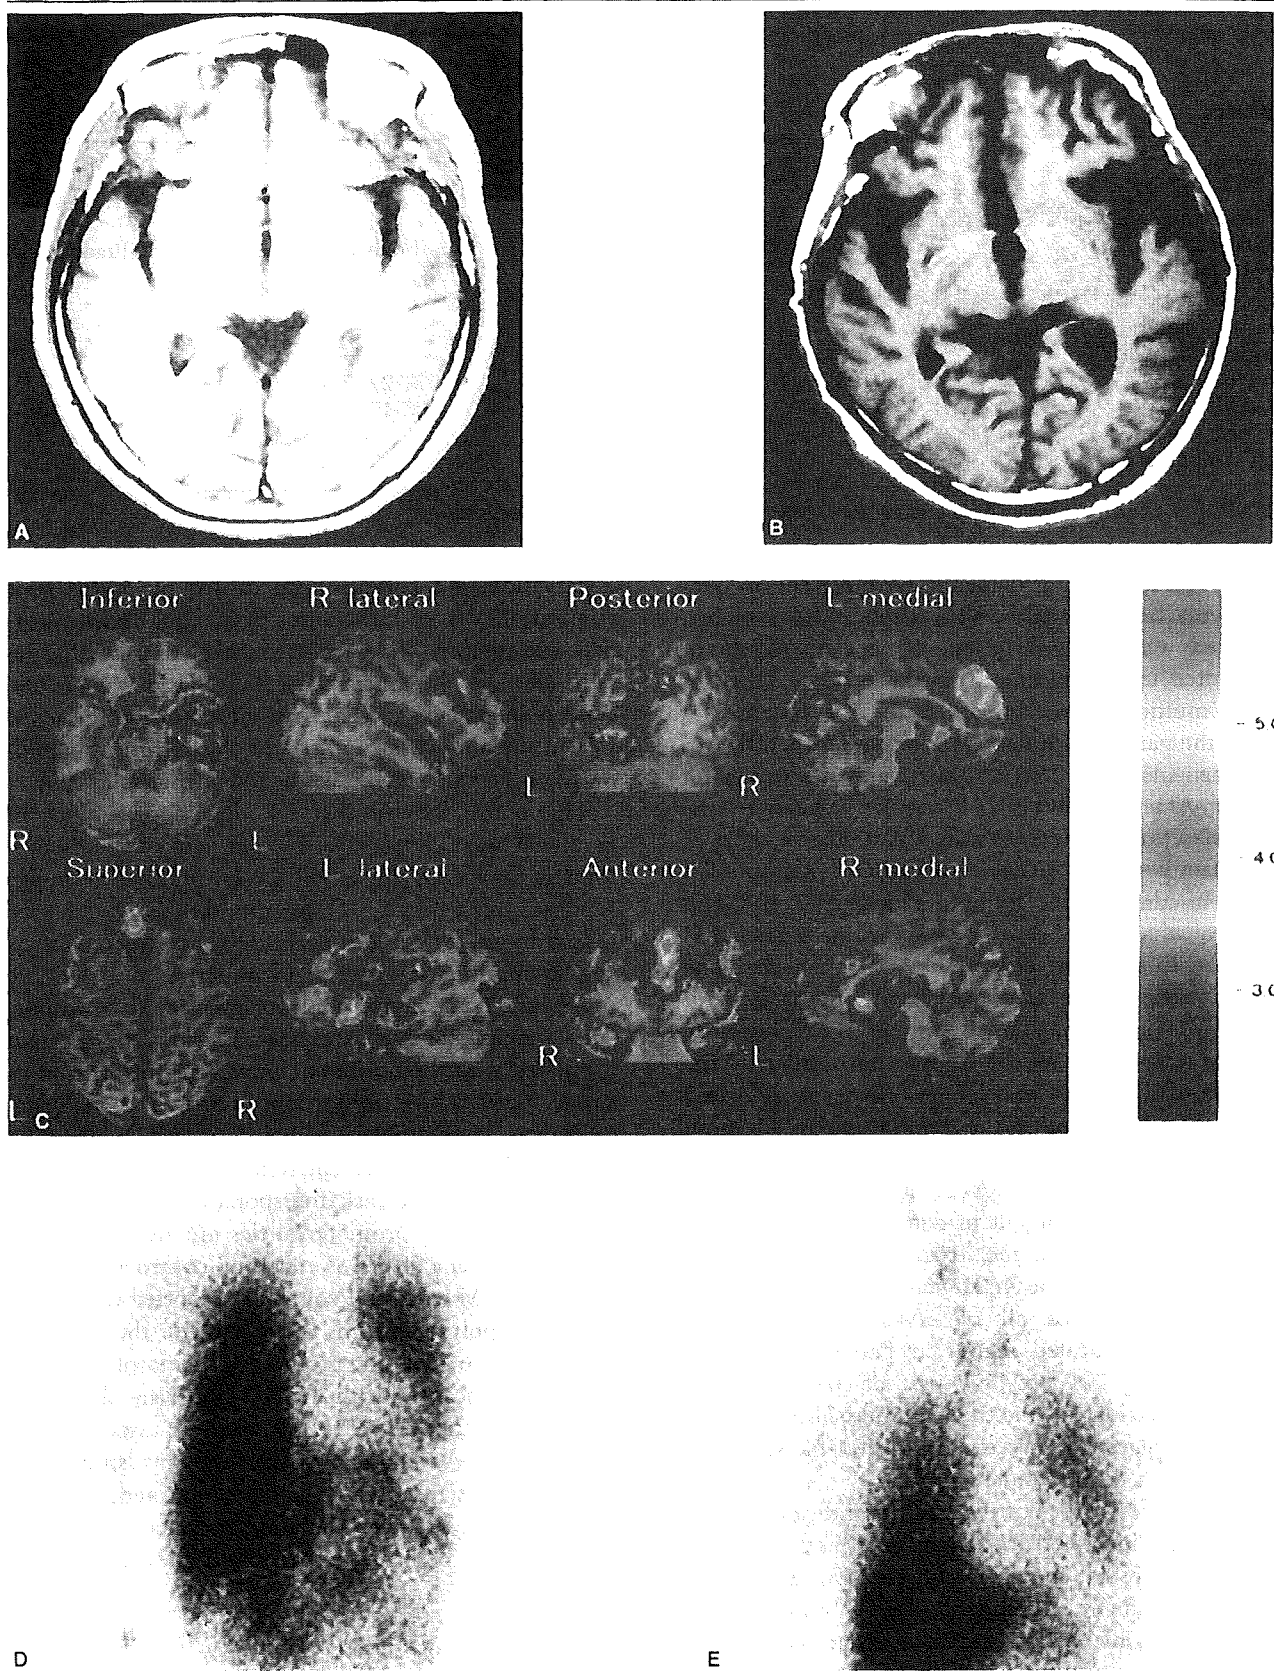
(A) Brain magnetic resonance imaging (MRI) T1 wedge study of Patient A-13. No abnormal masses or ischemic changes were evident. (B) Brain MRI T1 wedge study of Patient B-1. Note the dilation of Sylvian fissure and atrophic changes in both temporal lobes. (C)  $^{123}\text{I}$ -IMP SPECT study of Patient B-1. Note the hypoperfusion of both frontotemporal lobes and medial-occipital lobes. (D, E)  $^{123}\text{I}$ meta-iodobenzylguanidine (MIBG) myocardial scintigraphy (D; early, E; late) of Patient A-13. The H/M ratio was reduced in this patient.
